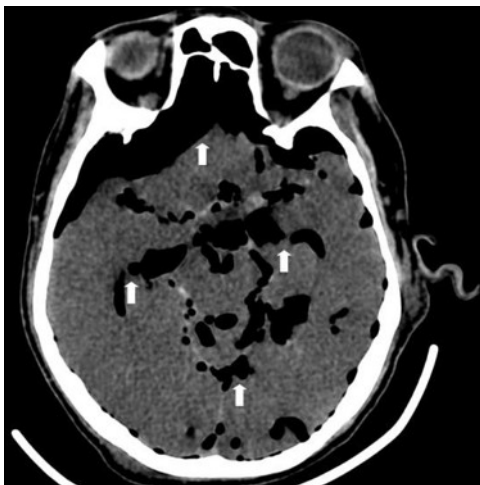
Plain Computed tomographic scan of the brain reveals extensive air locules (white arrow) within the cerebral hemispheres and ventricles.
